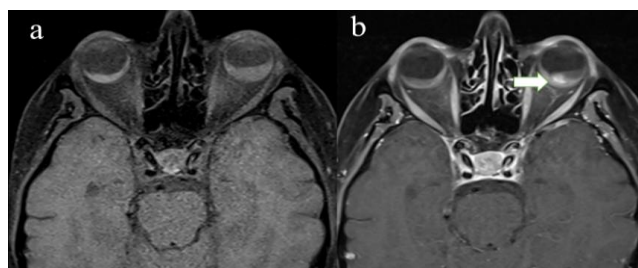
Axial pre-contrast (a) and postcontrast (b) fat-saturated T1-weighted fast-spin echo images of the left globe showing a nodular mass with contrast enhancement in the uvea along with retinal detachment, Case 2
